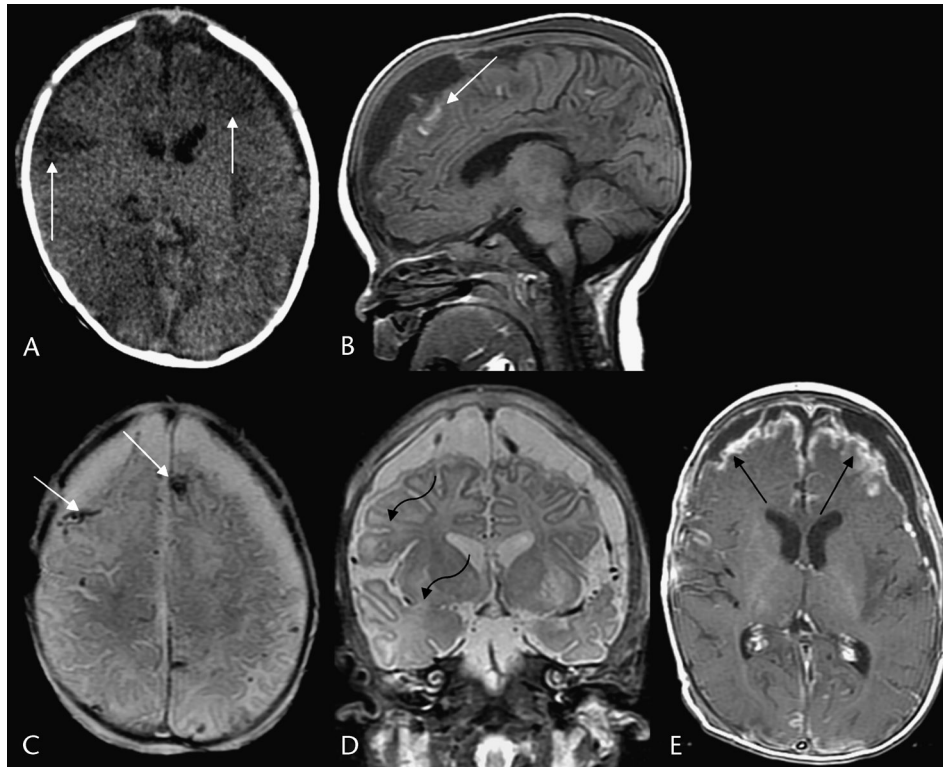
Pneumococcal meningitis in a 2-month-old boy. A, Noncontrast CT demonstrates multiple cortical and white matter hypodensities (white arrows) consistent with edema, cerebritis, or multifocal infarctions. Hyperdensities are consistent with hemorrhage or thromboses. The asymmetric extracerebral low densities likely represent subdural collections. Magnetic resonance imaging was done 1 week later. Sagittal T1 (B), axial GRE (C), coronal T2 (D), and axial postgadolinium T1 (E) images show T1-hypointense/T2-hyperintense extracerebral collections that are DWI hypointense (not shown). These likely represent subdural effusions, rather than empyemas. In addition, there is mild ventriculomegaly. Bilateral linear and nodular cerebral and extracerebral foci that are T1 hyperintense and T2/GRE hypointense (white arrows) represent hemorrhages or thromboses. Multifocal cerebral white matter and basal ganglia T2 hyperintensities likely represent edema or infarctions (curved arrows), and some show enhancement. Thick, irregular, leptomeningeal enhancement is seen over the convexities (black arrows) and along the basal cisterns.
